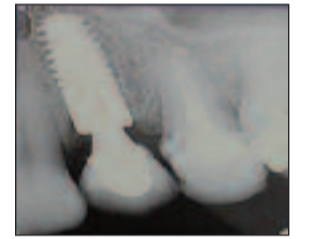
Post cementation radiograph
